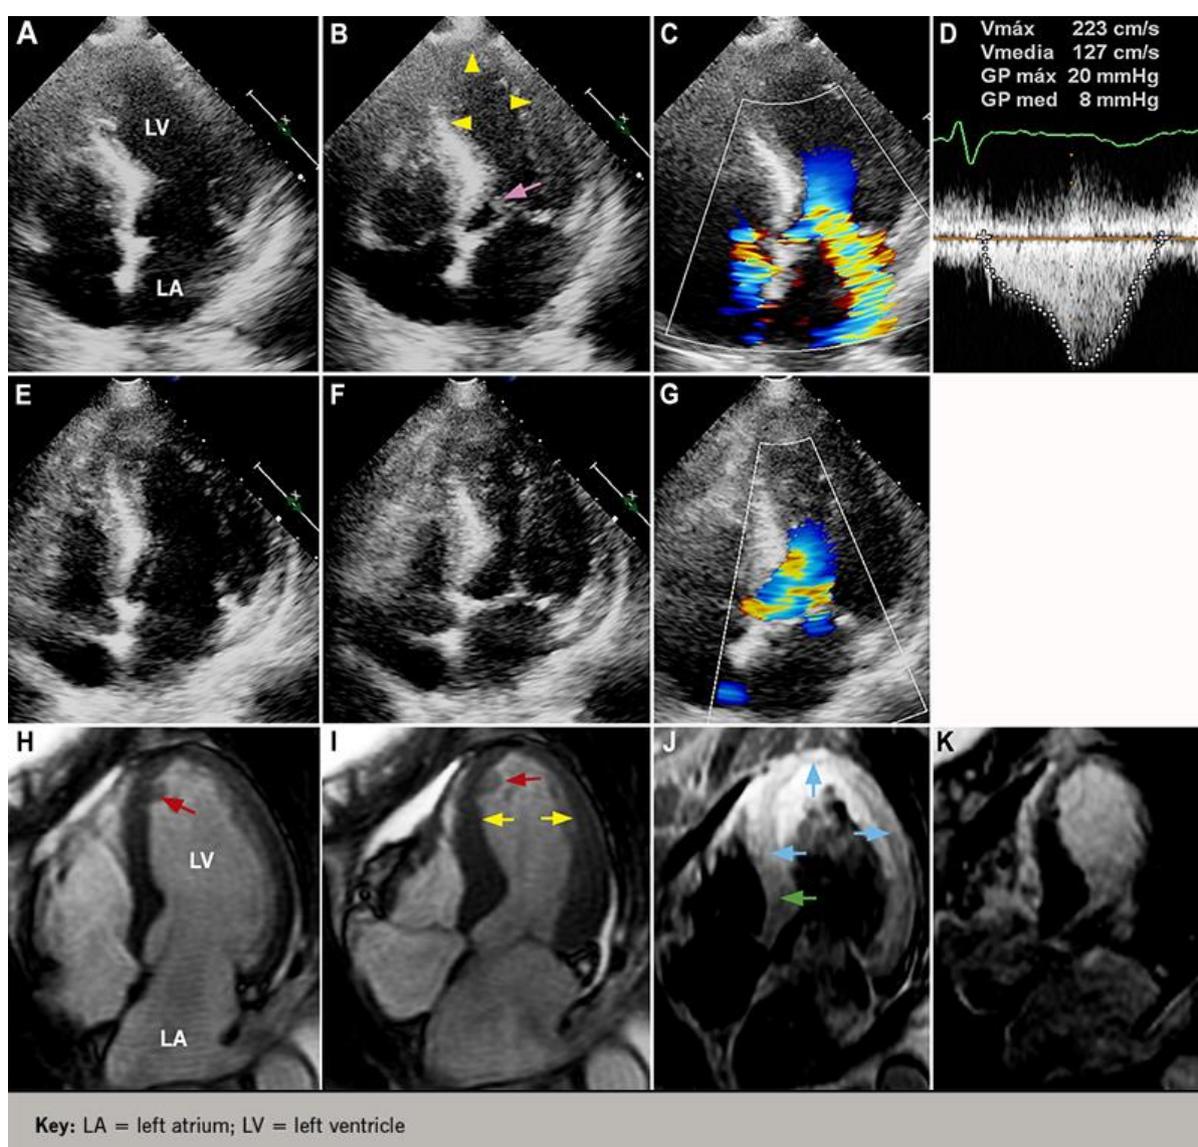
Show Echocardiogram of patient Left Ventricle.
